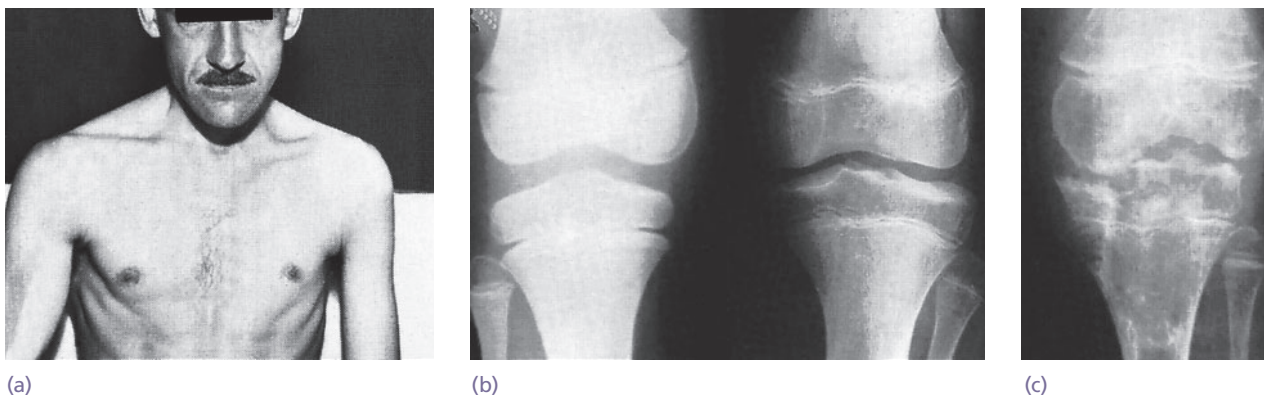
Tuberculosis – clinical and X-ray features (a) Generalized wasting used to be a common feature of all forms of tuberculosis. Nowadays, skeletal tuberculosis occurs in deceptively healthy-looking individuals. An early feature is periarticular osteoporosis due to synovitis – the left knee in (b). This often resolves with treatment, but if cartilage and bone are destroyed (c), healing occurs by fibrosis and the joint retains a 'jog' of painful movement.
